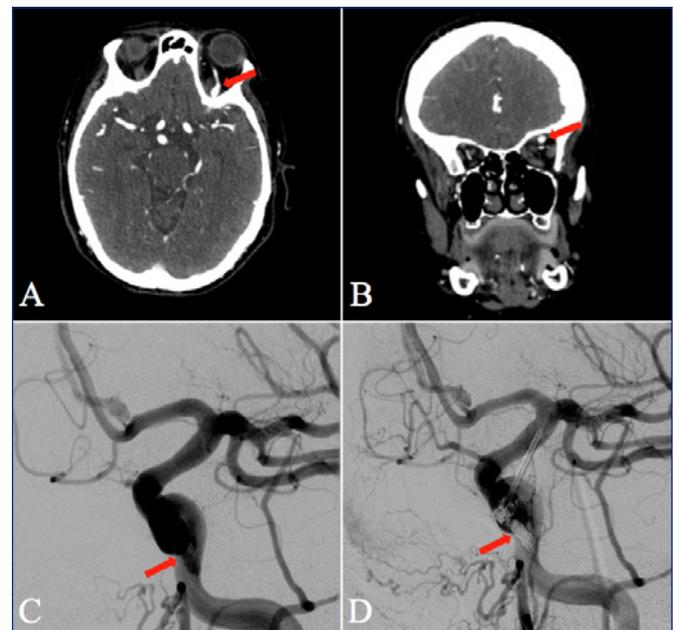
Computed Tomography Angiography (CTA) with coronal (A) and axial (B) views of the dilated left superior ophthalmic vein. Interventional angiograms with arrows demonstrating the patent fistula (C) and the resolved fistula following coil embolization (D).
